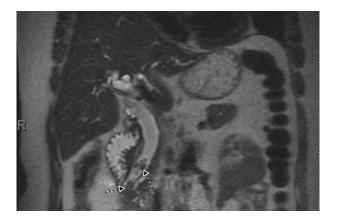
MRI showing filing defects in the distal common bile duct and ampulla.
